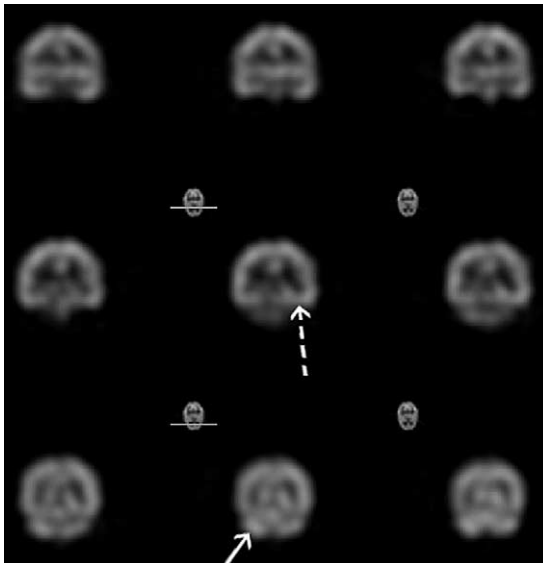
Ictal Tc-HMPAO (Technetium-99m hexamethylpropylene amine oxime—99m Tc-HMPAO) single photon emission computed tomography scan (coronal images) shows increased tracer uptake in the left temporal lobe (*dashed arrow*) and right cerebellar hemisphere (*solid arrow*) (crossed cerebellar diaschisis).
